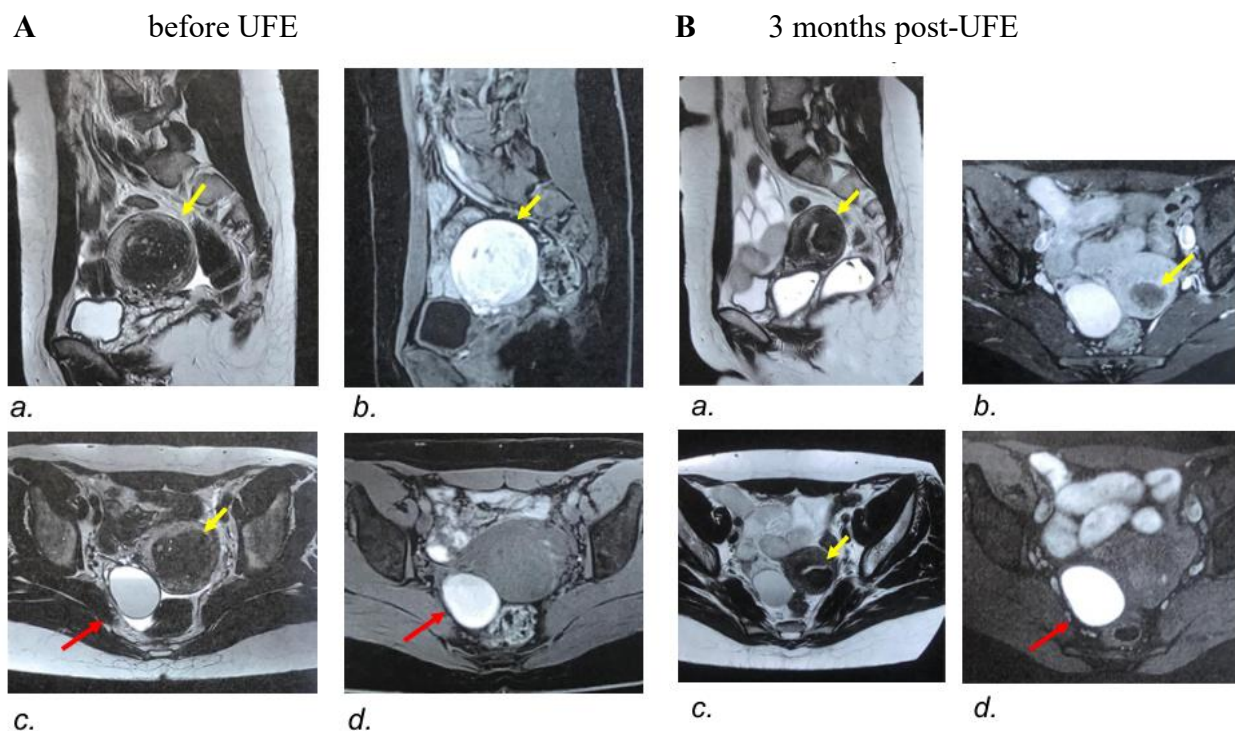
Fig A Pre-UFE MRI scans reveal an adenomyoma (yellow arrow) and a right ovarian endometrioma (red arrow) across different imaging views: (a) T2-weighted sagittal, (b) contrast-enhanced sagittal, (c) axial T2, and (d) axial T1 fat-saturated. Fig B Follow-up scans three months after UFE show successful treatment, with the adenomyoma shrinking and showing signs of necrosis in matching views: (a) T2 sagittal, (b) contrast-enhanced axial, (c) axial T2, and (d) axial T1 fat-saturated.
